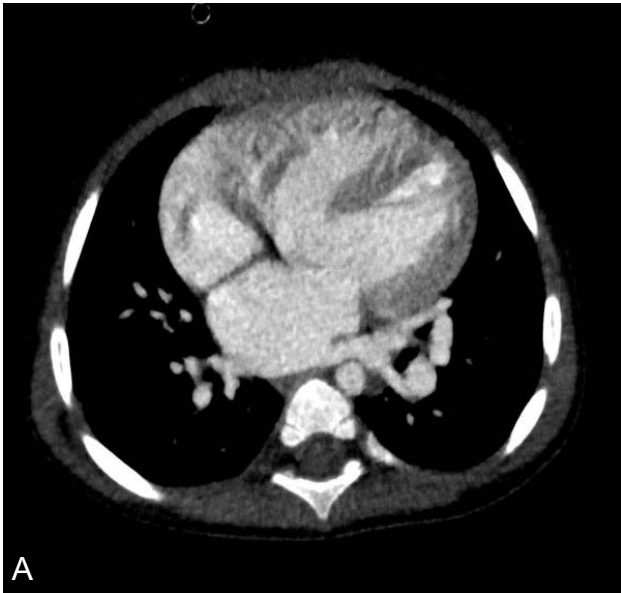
CT post contrast axial image showing a large membranous interventricular septal defect. Figure B: CT post contrast coronal image Over-riding of aorta is clearly seen with aortic annulus receiving contrast from both the right and left ventricles.
